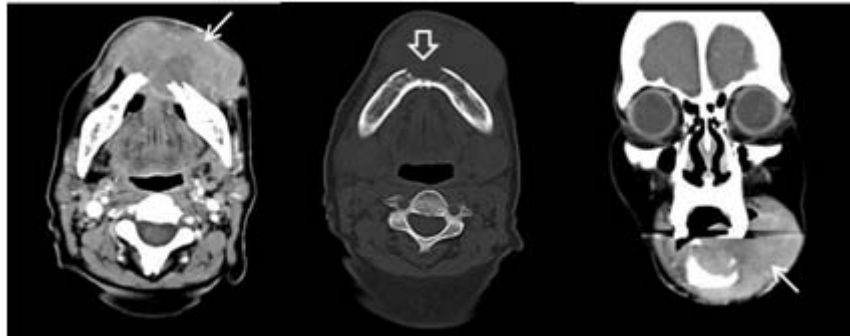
NHL of mandible in patient with HIV infection. Axial and coronal enhanced CT scan showed heterogeneous enhancing mass at mandible (arrow) with bony destruction (open arrow) and multiple cervical lymphadenopathy. Pathology was lymphoblastic lymphoma. CT scan of abdomen (not shown) revealed hepatosplenomegaly that classified this patient as stage IV lymphoma.
